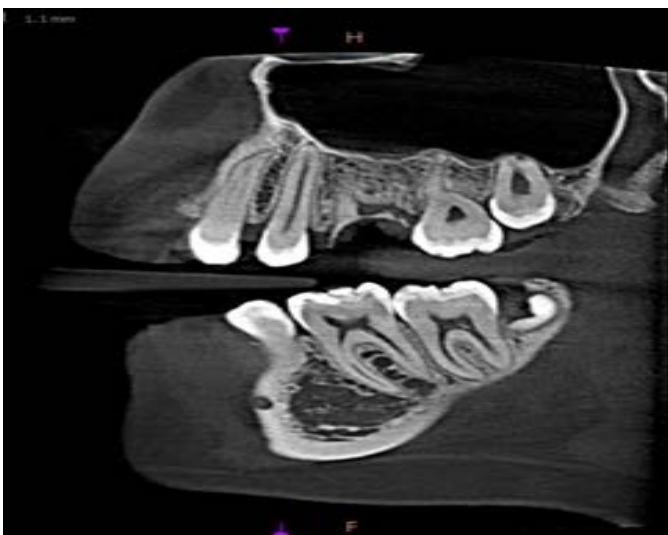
sagittal section of image showing grossly decayed 16 with periapical rarefaction. Absence of artifacts noticed. degree 0 (g0).
